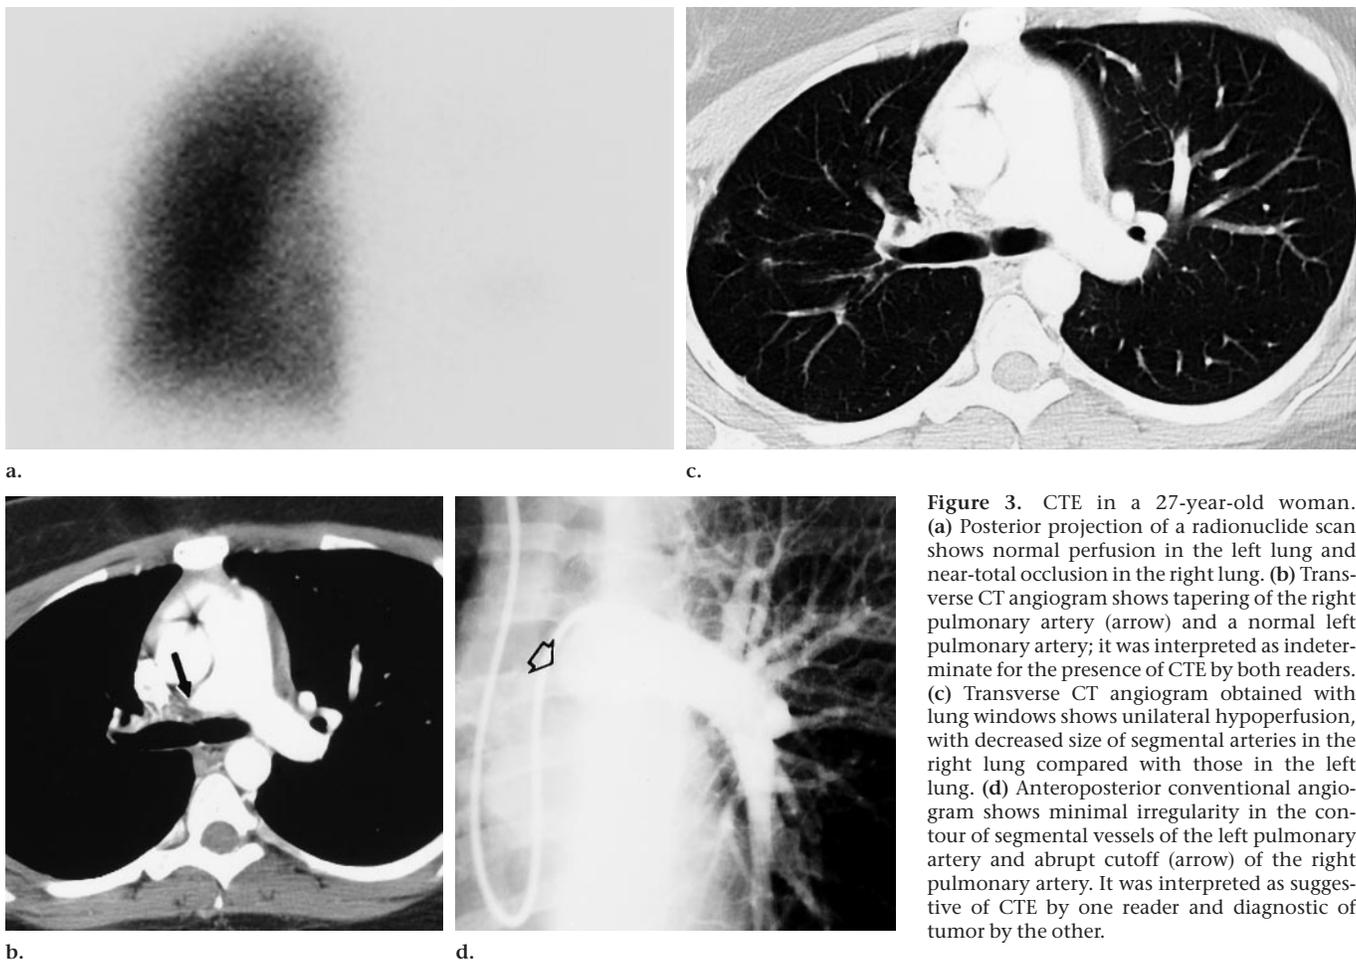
CTE in a 27-year-old woman. (a) Posterior projection of a radionuclide scan shows normal perfusion in the left lung and near-total occlusion in the right lung. (b) Transverse CT angiogram shows tapering of the right pulmonary artery (arrow) and a normal left pulmonary artery; it was interpreted as indeterminate for the presence of CTE by both readers. (c) Transverse CT angiogram obtained with lung windows shows unilateral hypoperfusion, with decreased size of segmental arteries in the right lung compared with those in the left lung. (d) Anteroposterior conventional angiogram shows minimal irregularity in the contour of segmental vessels of the left pulmonary artery and abrupt cutoff (arrow) of the right pulmonary artery. It was interpreted as suggestive of CTE by one reader and diagnostic of tumor by the other.
